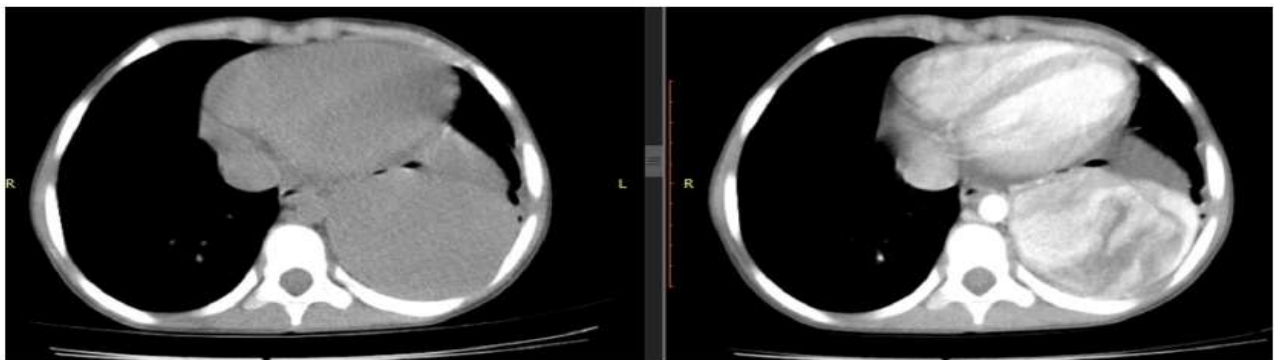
Chest CT Scan and Angiography Showing Left Pleural Based Mass Having Heterogeneously Contrast Enhancing Mass.
